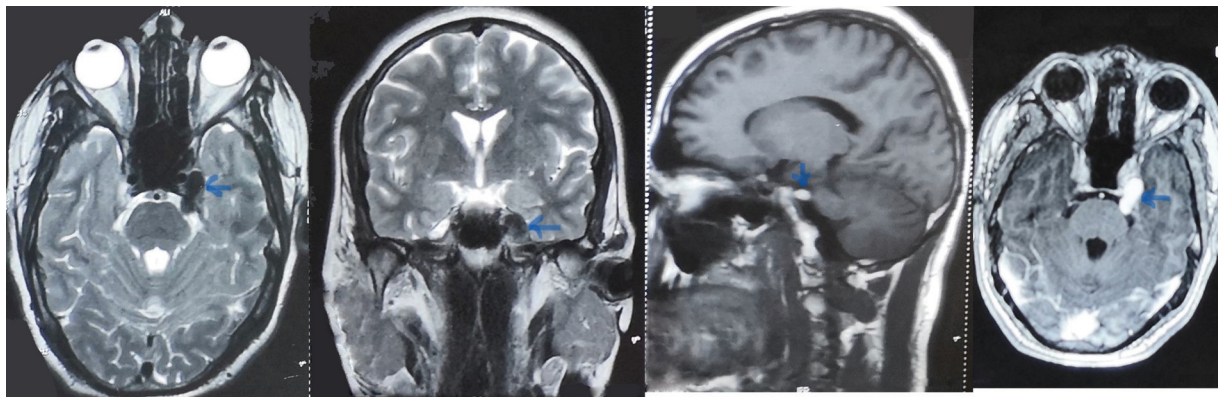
A 9-month-old sagittal T1-weighted image showing hyperintense lesion (blue arrow), axial T2-weighted image showing hypointense lesion (blue arrow), coronal T2-weighted image showing hypointense lesion (blue arrow), and axial T1 with gadolinium contrast images showing homogenous enhancement of lesion (blue arrow).
